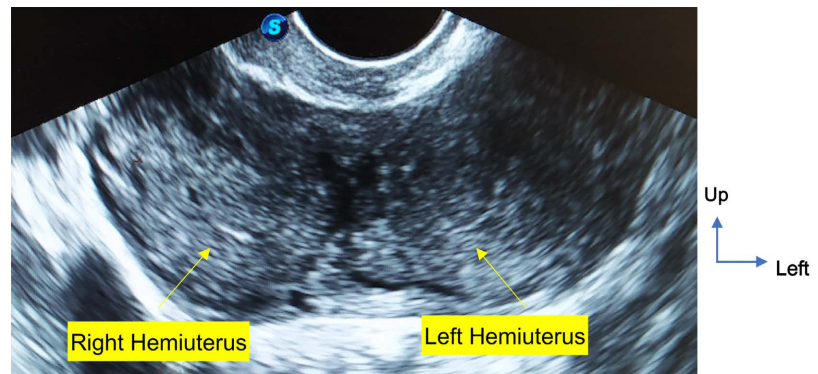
Vacuity of both hemi horns on ultrasound after medical treatment (Picture Hôpital Principal de Dakar).
